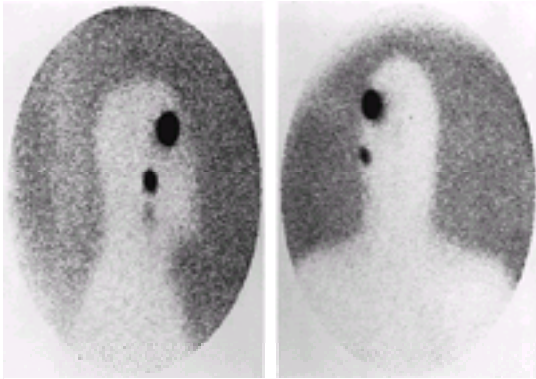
Lymphoscintigram after injection of technetium-labeled sulfur colloid around a right forehead melanoma. The tracer localized a sentinel lymph node in the preauricular area.
